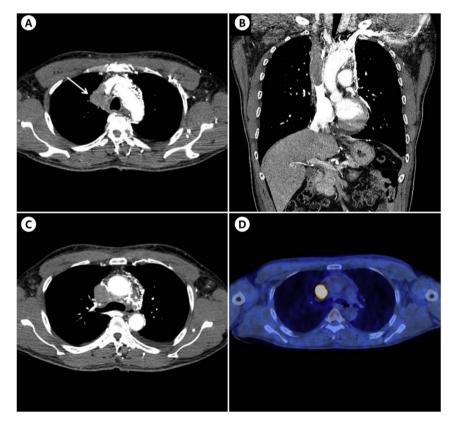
Chest computed tomography (CT) scan shows 38 mm primary lung mass invading the right mediastinum (arrow) (A). On coronal image, SVC mass is extended to the right atrium (B). Transverse lung window CT image shows the mass fully occupying the SVC (C). PET-CT images shows FDG uptake with SUVmax of 10.6 on the SVC mass (D).
